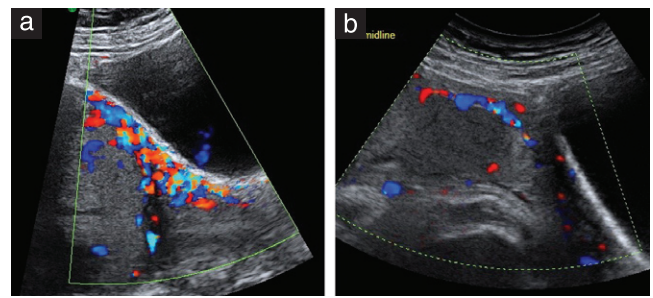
Uterovesical hypervascularity (a) and a normal example for comparison (b) on color Doppler imaging.
